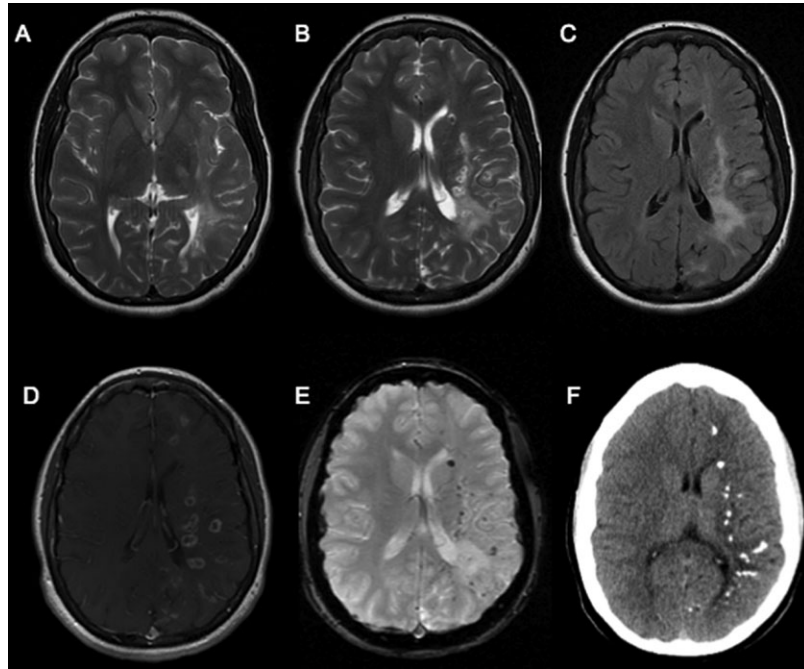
Findings on magnetic resonance imaging (MRI) and computed tomography (CT) of the brain at second presentation. MRI brain showing increased T2 (A, B) and fluid attenuated inversion recovery sequence (FLAIR) signal intensity lesions (C) in the deep white matter of the left hemisphere and in the subcortical white matter of the left temporal region. Enhancing calcifications are seen in the deep white matter of the left hemisphere on post-gadolinium T1 (D) and high-resolution T2 gradient echo (E), as well as on CT scan (F).
